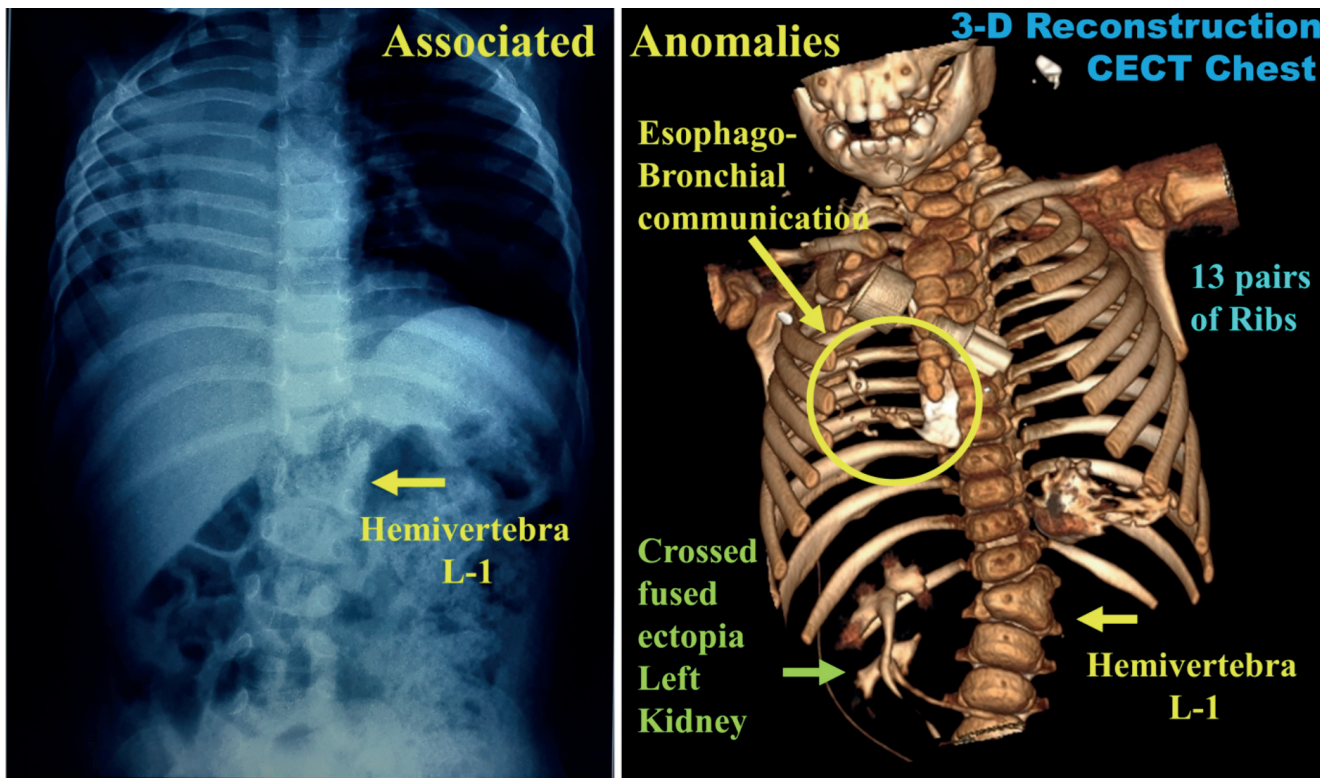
Associated anomalies. Lumbar vertebral anomaly on plain X-ray, 13 pairs of ribs and crossed fused ectopia of left kidney on 3-D reconstruction of contrast enhanced computed tomography chest and abdomen.
